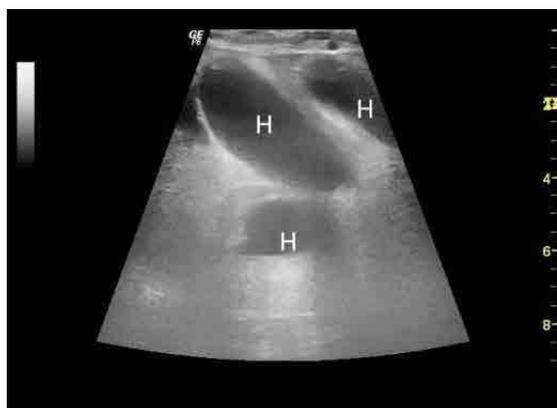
Ultrasonography: left kidney, multiple anechoic fluid spaces (H).
